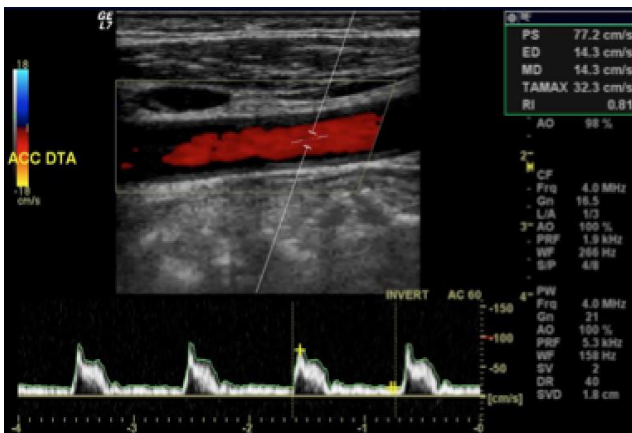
Pulsed Wave Doppler of Common Carotid Artery- Hemodynamic Variables measurement.
